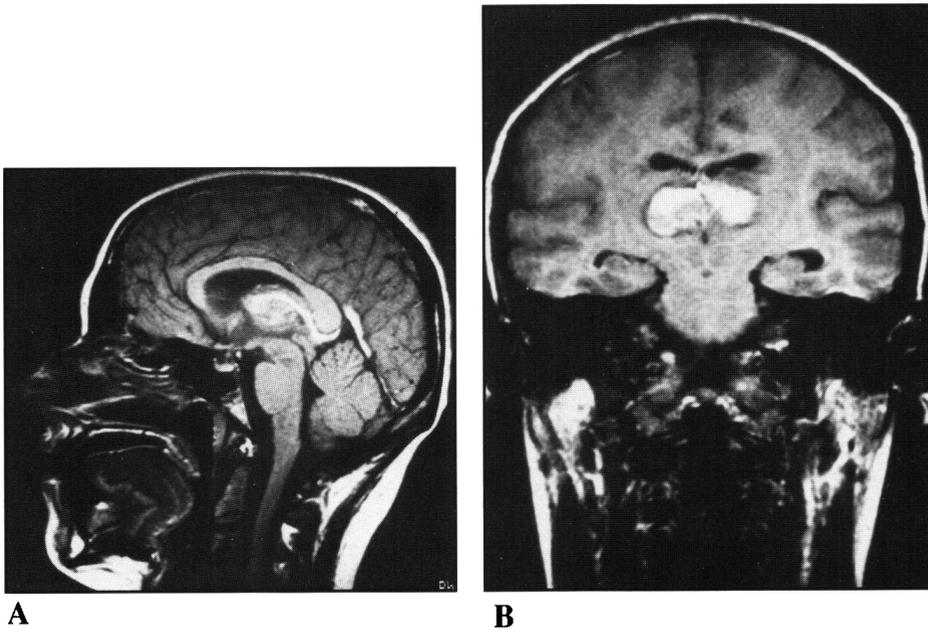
(A and B) — Patient 2 — T1-weighted SE MR (TR = 550ms, TE = 30ms) ten days after admission. Hyperintensity in the internal cerebral veins, vein of Galen, straight sinus and mid-posterior sagittal sinus. Globular hyperintensity with rim hypointensity, characteristic of subacute hemorrhage¹ in medial thalami, as well as in left caudate nucleus, internal capsule and globus pallidus (not shown).
